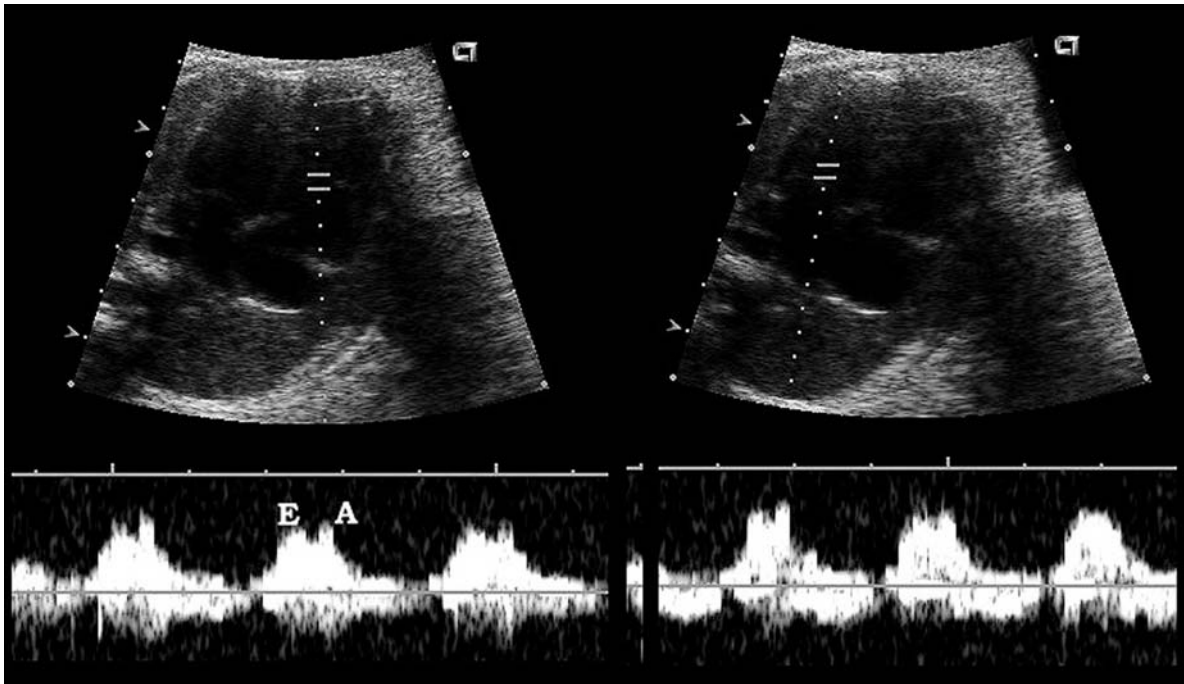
Gray-scale image of a color Doppler axial scan through the fetal chest at 25 weeks showing flow across the AV valves
